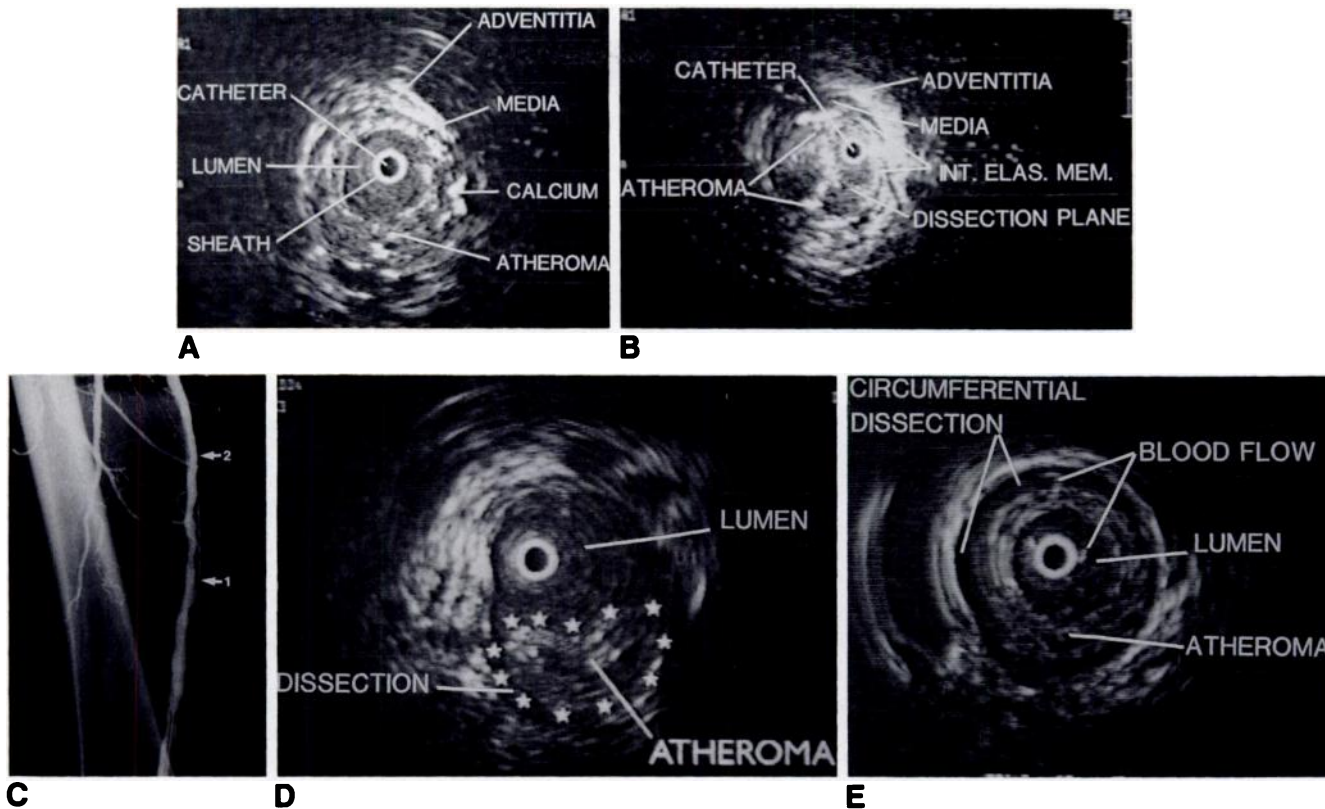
A, Intravascular sonogram in distal superficial femoral artery before entering area of recanalization. Central black area is from catheter; around this is a white echo reflection from plastic sheath. In a radial distribution is echolucent lumen, then a thick atheroma with variable echo reflections depending on amount of collagen within plaque or presence of calcium.
